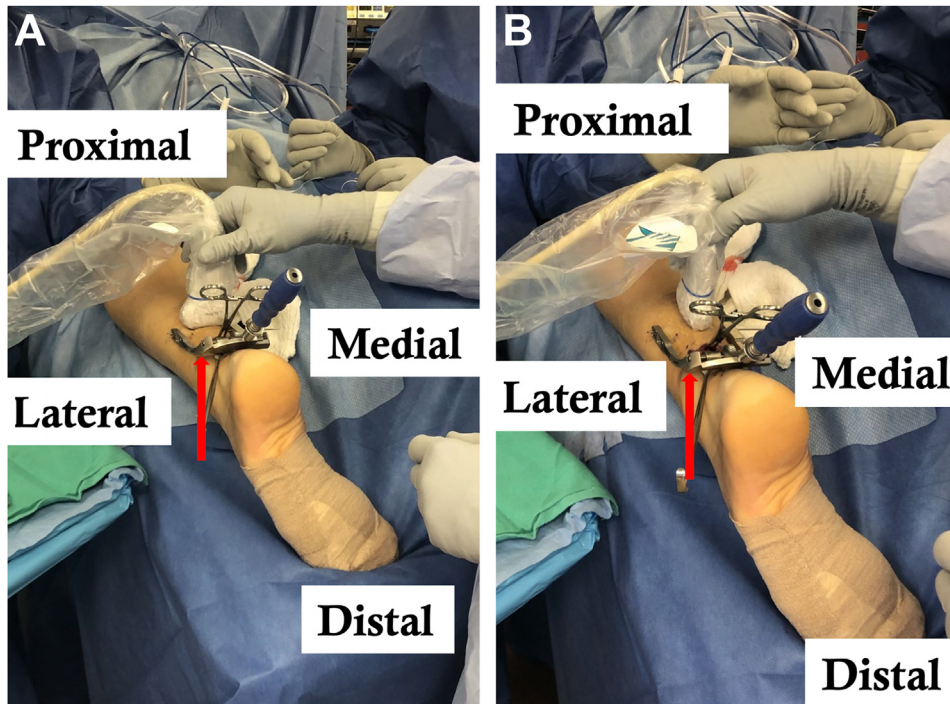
Viewing the posterior aspect of the left ankle and foot. The leg has been prepped and draped in the standard sterile fashion, and the patient is lying on the operative table in the prone position. The ultrasound probe is positioned over the posterior aspect of the ankle, overlying the Achilles tendon, at the level of the ankle surrounding the Achilles injury. This image demonstrates the intraoperative ultrasound visualization with the Percutaneous Achilles Repair System (PARS) jig system (red arrow). (A) Intraoperative ultrasound visualizing the Achilles tendon and nearby neurovascular structures in the short-axis view. (B) Intraoperative ultrasound visualizing the Achilles tendon and nearby neurovascular structures in the long-axis view.
